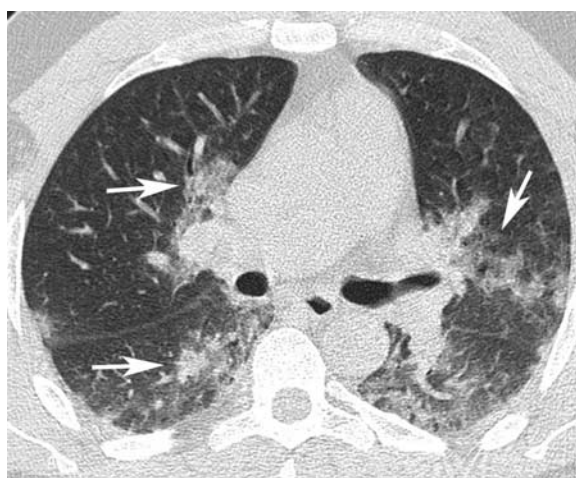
Mycoplasma pneumoniae* pneumonia. HRCT of a 36-year-old man with *Mycoplasma pneumoniae* pneumonia shows bilateral lobular ill-defined ground-glass opacities (arrows). HRCT indicates high-resolution CT.
